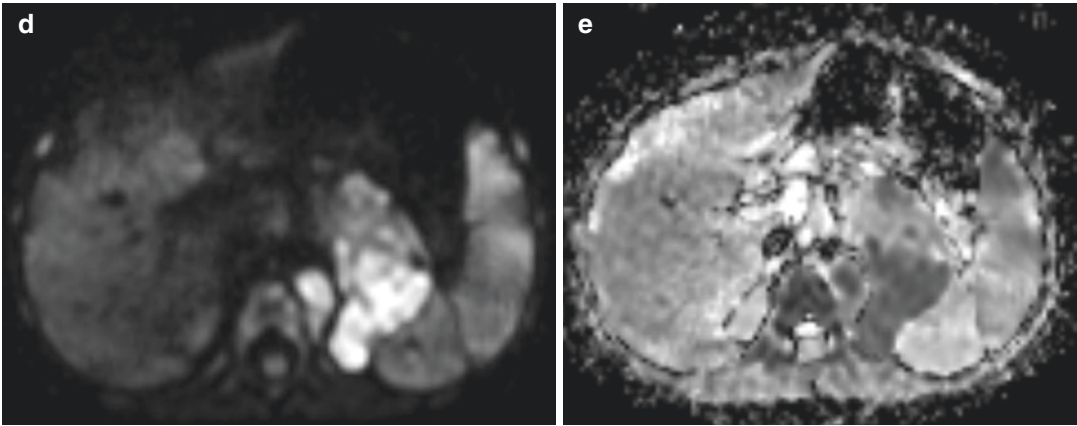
Whole-body MRI in a 3-year-old boy diagnosed with stage IV neuroblastoma (same patient as Fig. 7.4). Coronal 3D T2-weighted turbo spin-echo (T2-TSE) image (a) with sagittal reconstruction (b) demonstrates the primary tumor arising from the left adrenal gland with retroperitoneal extension (white arrows in a), vascular encasement (arrowheads in a and b), and lifting
